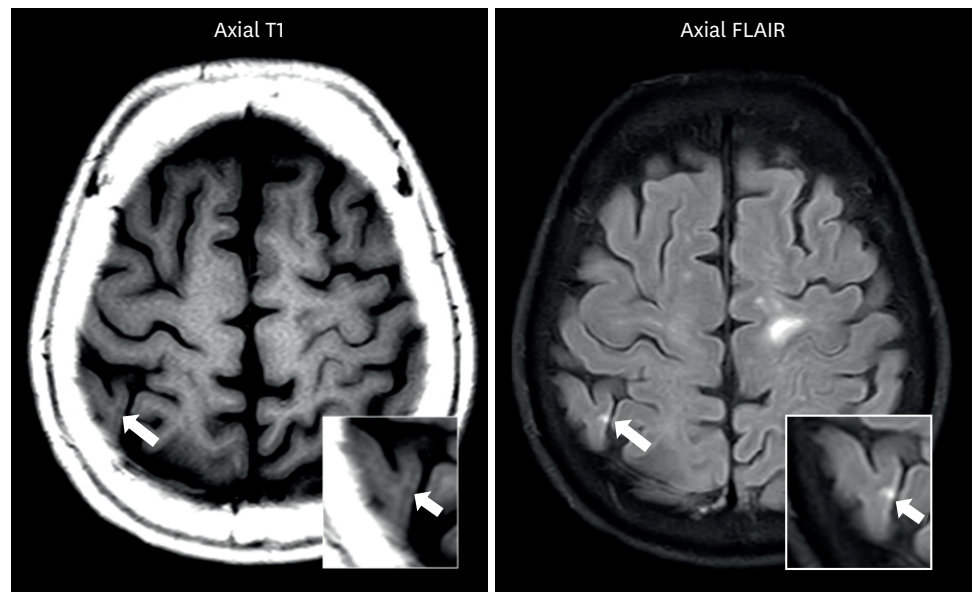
Example of CMIs on a 3T brain magnetic resonance imaging. The CMIs (arrow) were shown as a hypointense on T1-weighted image and as a hyperintense on FLAIR image. CMI, cortical cerebral microinfarct; FLAIR, fluid attenuated inversion recovery.
